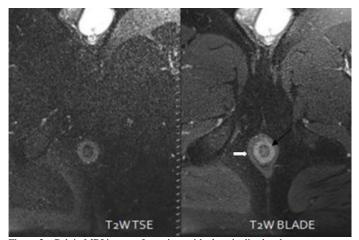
Pelvic MRI image of a patient with chronic diarrhea by transverse plane fat-suppressed T2-weighted (T2-W) turbo spin echo (TSE) sequence and T2-W BLADE sequence.
